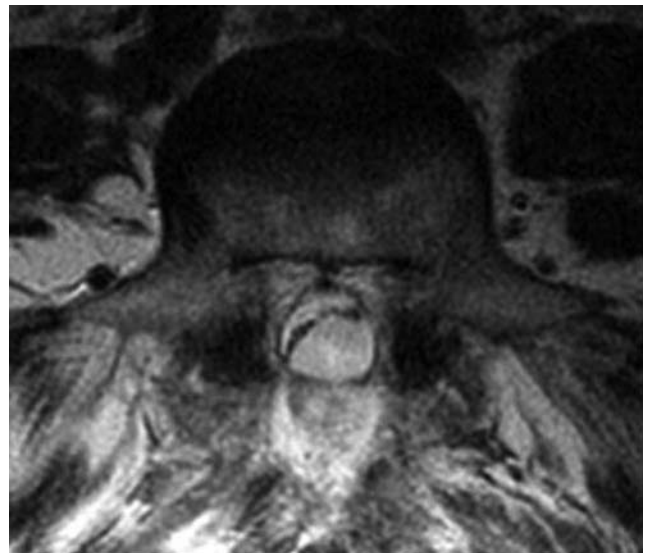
Case 2. Axial MR image showing an arachnoid cyst causing intradural compression of the cauda equina.
